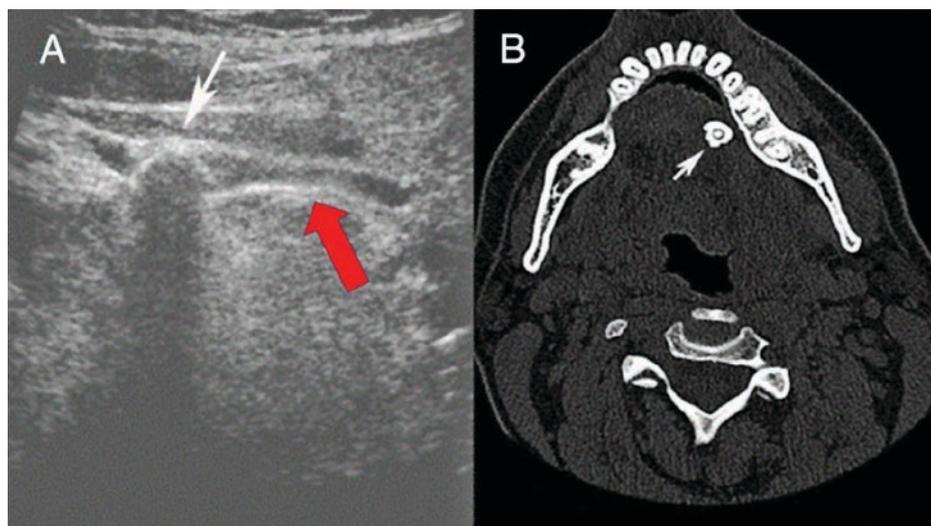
A) Display of stone and dilatation of the Wharton's duct; B) CT axial view of a stone in the left submandibular gland, size 1 cm
